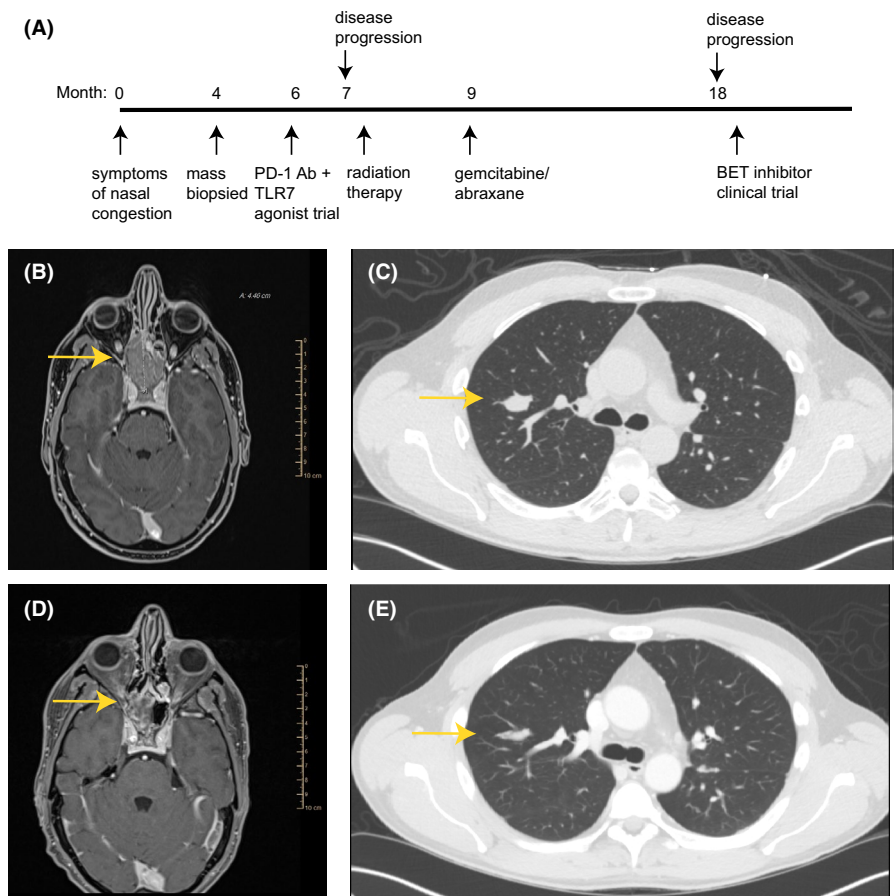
A, Timeline of diagnosis and treatment course. B, Baseline MRI Brain with and without contrast demonstrating sphenoid sinus mass. C, Baseline chest CT demonstrating pulmonary nodule. D, MRI Brain with and without contrast after 2 cycles of gemcitabine and nab-paclitaxel. E, Chest CT after 2 cycles of treatment
